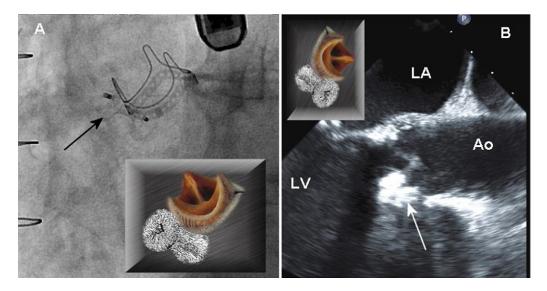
Panel A: Angiographic imaging of the paravalvar defect closure device (black arrow) adjacent to the aortic prosthesis. The orientation of the devices is demonstrated in the inset panel. Panel B: Omniplane transoesophageal echocardiographic imaging of the paravalvar defect closure device (white arrow) adjacent to the aortic prosthesis (Ao: aorta; LA: left atrium; LV: left ventricle).
